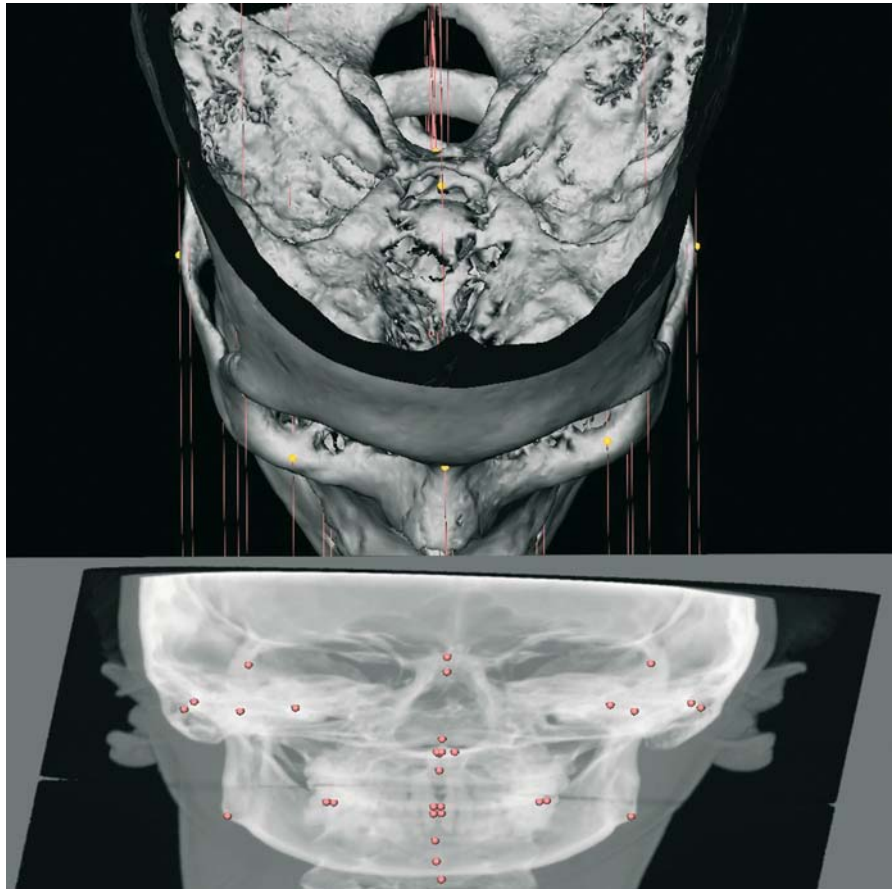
Set-up of 3-D cephalometric hard tissue landmarks. Virtual lateral cephalogram (3-D CT, patient K.C.)
